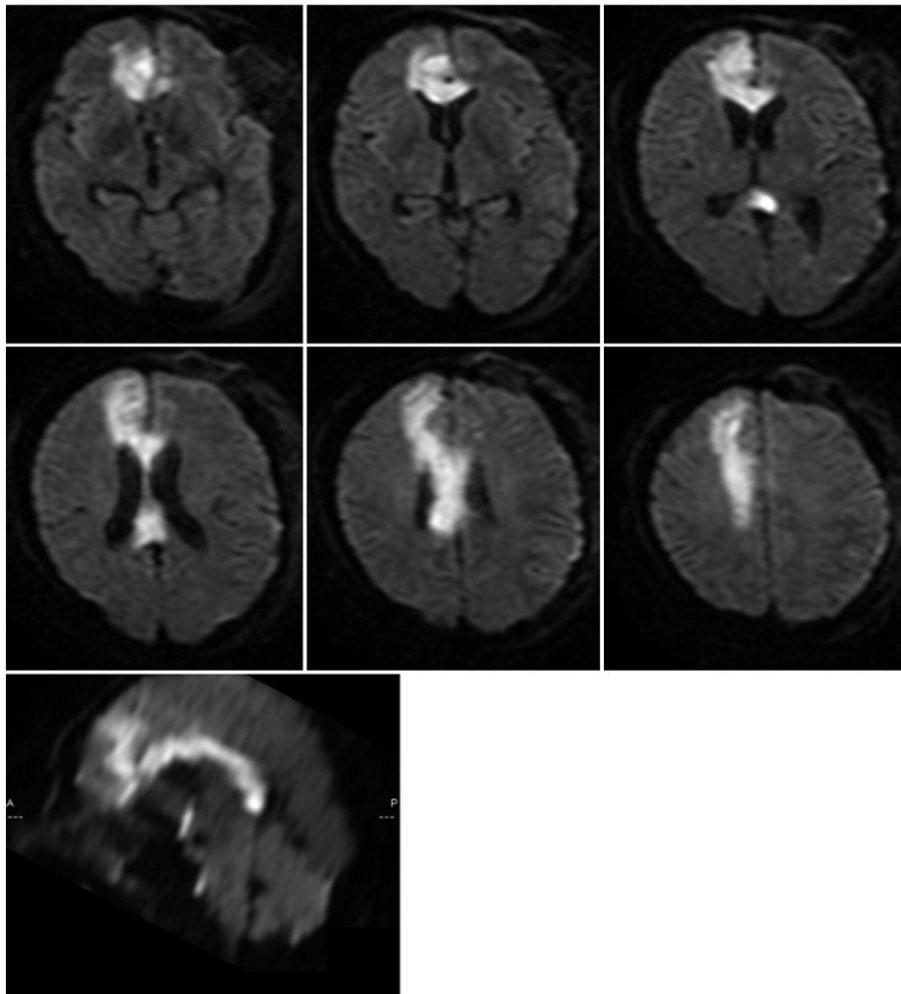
Diffusion-weighted magnetic resonance images in the axial (top and middle) and sagittal (bottom) planes in which infarction of the entire length of the corpus callosum and medial aspect of the right frontal lobe can be detected.
